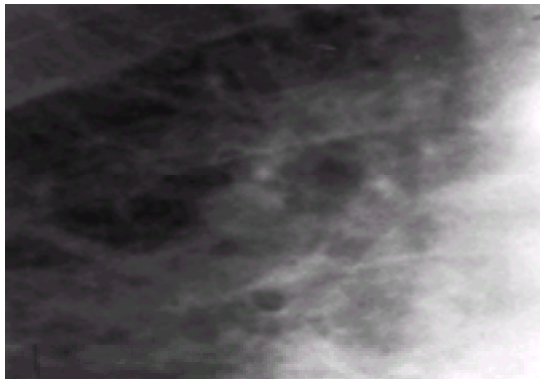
Detail of a chest radiograph of a patient with pulmonary oedema to demonstrate 'peribronchial cuffing'—a variant of the 'air-bronchogram' sign.
